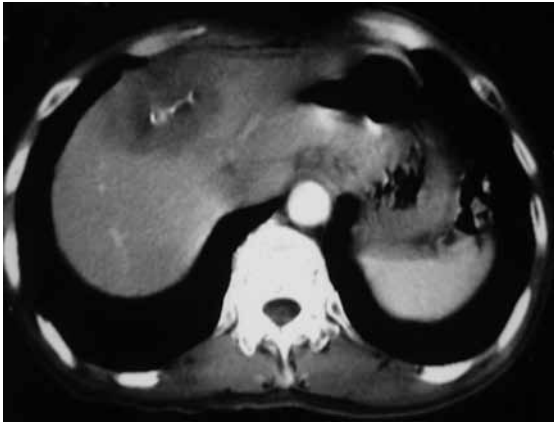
CT image shows a hypodense lesion in the right lobe with central calcifications (local form) in an elderly man who presented with a long history of right upper quadrant pain and weight loss who was investigated for suspected hepatocellular carcinoma as he was also suffering from chronic hepatitis B. Serum alpha fetoprotein was normal. The patient declined biopsy of the lesion, with resultant delayed diagnosis. The diagnosis of TB infection was made only when the patient presented with bleeding per rectum, and colonoscopy showed ileocecal tumours that turned out to be TB. The patient remained well after treatment without further bleeding.
